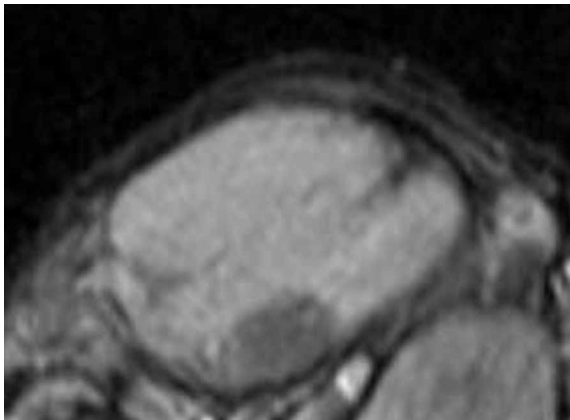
MRI imaging, right testis, three years after left-sided orchietomy, one year after surgical evaluation of this testicle. T1-weighted image, fat suppression, contrast media application. The intratesticular mass has gained in size. Repeat surgery now reveals solid seminoma.
